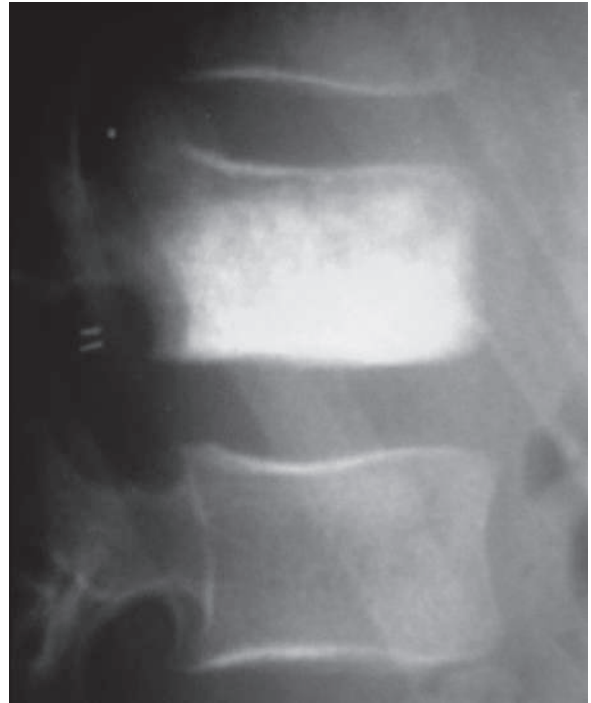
Lateral plain thoracic vertebral radiograph shows complete sclerosis of a single vertebra (ivory vertebra). The differential diagnosis of ivory vertebra includes lymphoma infiltrating the vertebral body, Paget's disease, and metastases infiltrating the vertebral body
